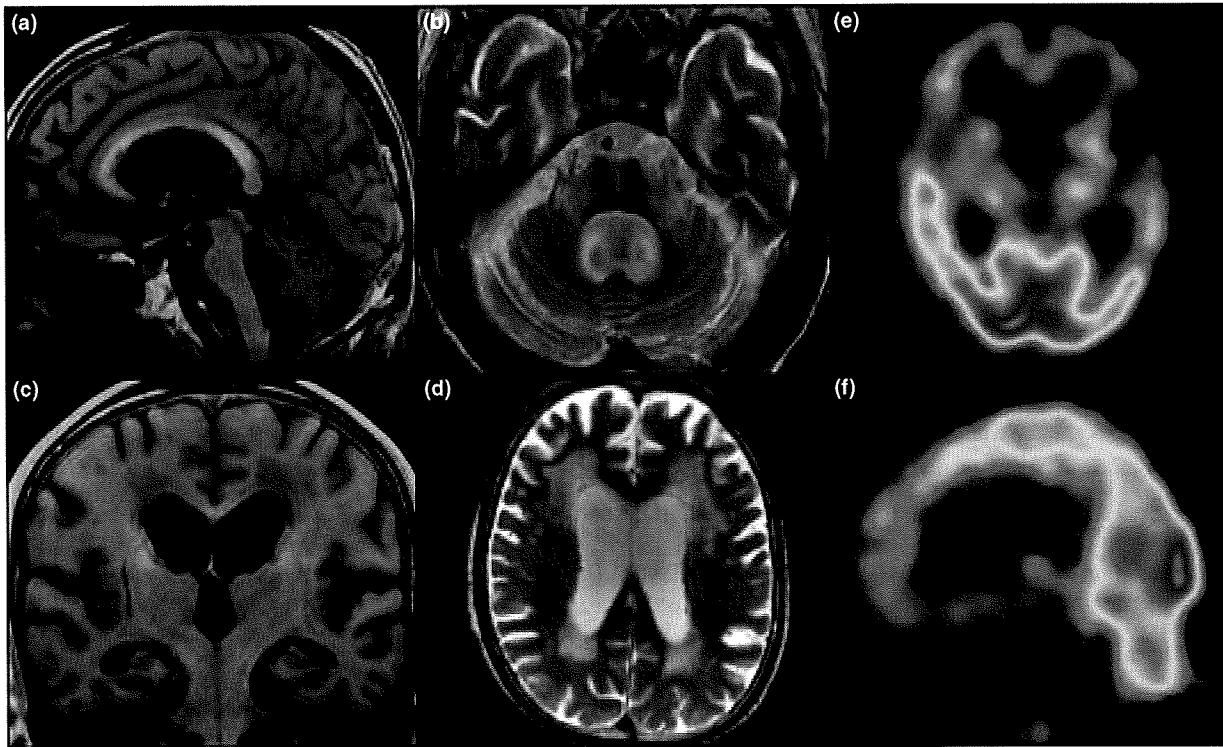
Neuroimaging studies at case 9. (a–d) Magnetic resonance imaging (MRI) revealed severe cerebellar and pontine atrophy with the so-called 'hot cross bun sign,' severe fronto-temporal lobe atrophy and moderate white matter lesions [Correction added after online publication 31 March 2009: in the preceding sentence, 'burn' was corrected to 'bun']. (e, f) 99mTc-ECD SPECT image showed severe decline of regional cerebral blood flow in the frontal and temporal lobes. (a, c) T1 weighted MRI image (b, d) T2 weighted MRI image.
